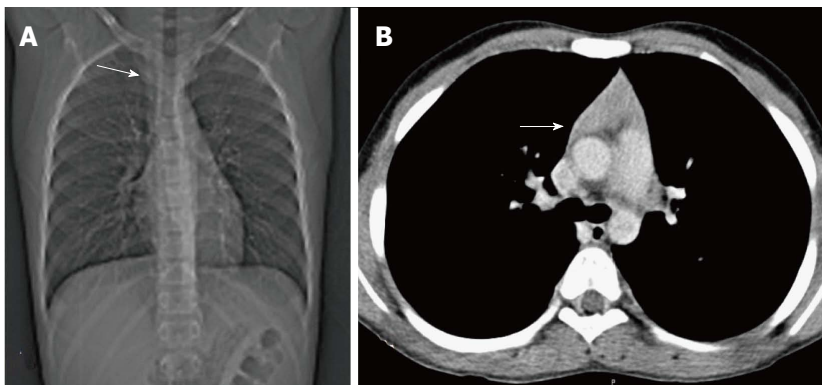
Thymic hyperplasia in a 12-year-old boy treated for Hodgkin's lymphoma for 8 mo. CT scanogram (A) shows subtle mediastinal widening (arrow). CECT axial section (B) shows mild thymic enlargement with convex margins and homogenous density (arrow) consistent with rebound hyperplasia.
